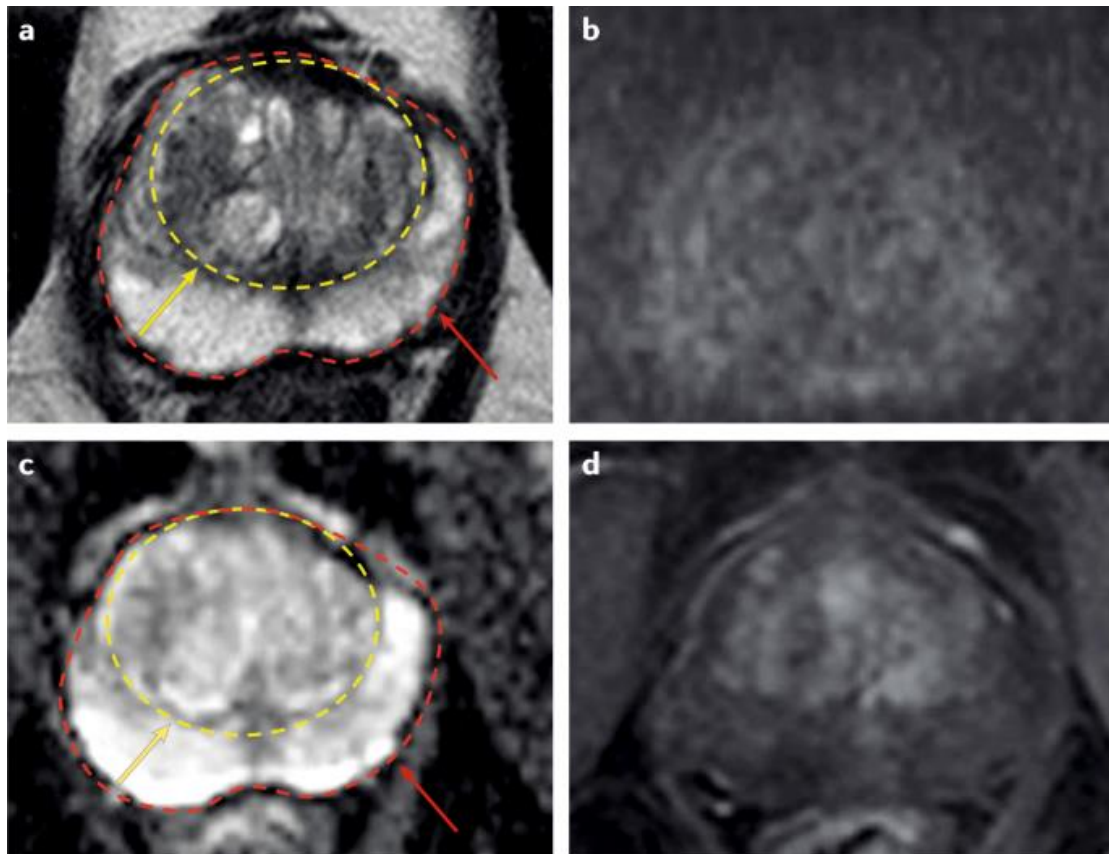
Multiparametric MRI scan images of a patient without prostate cancer(30). Yellow circle indicates the border of the transitional zone. Red border indicates the edge of the peripheral zone.
